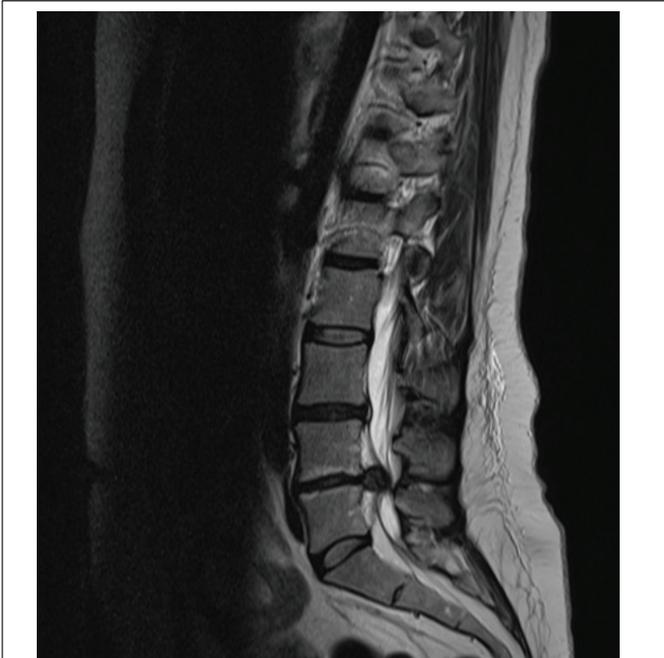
CInitial MRI showing the large ruptured disc at the L4–L5 level with extrusion of the nucleus pulposus and nerve root compression.
